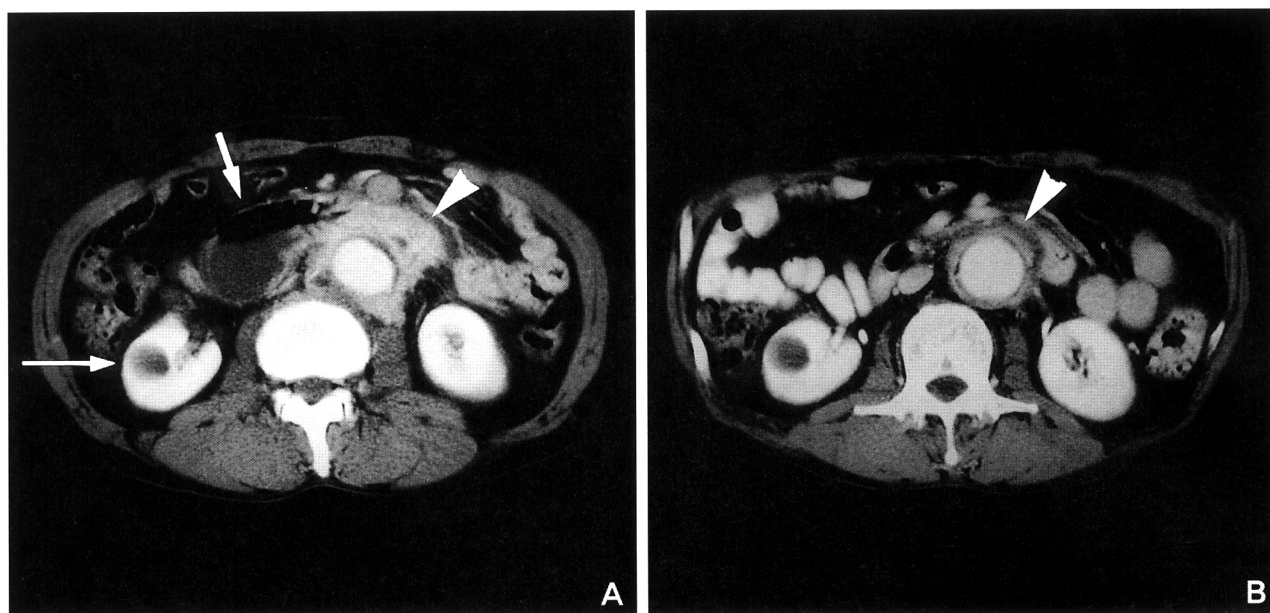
Abdominal CT scan before and after treatment. A: Initial, pretreatment scan reveals a huge periaortic retroperitoneal mass (arrow head) and consequent duodenal stenosis (thick arrow) and incidental right renal cyst (thin arrow). B: After 3 weeks of prednisolone therapy, the mass has markedly decreased in size (arrow head) and duodenal stenosis was improved.
